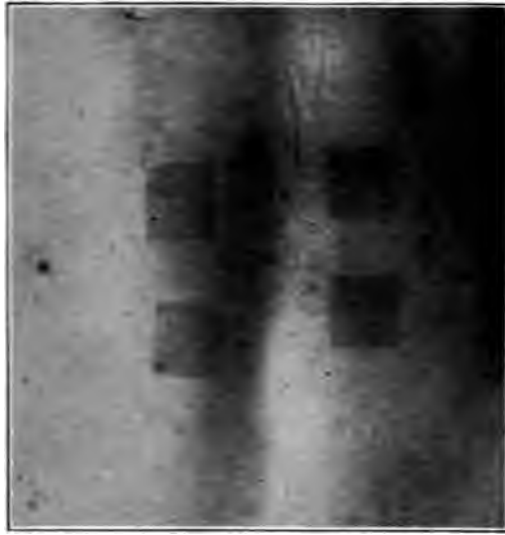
Four areas of x-ray erythema all of which are apparently of the same degree. Explanation will be found in the text.
